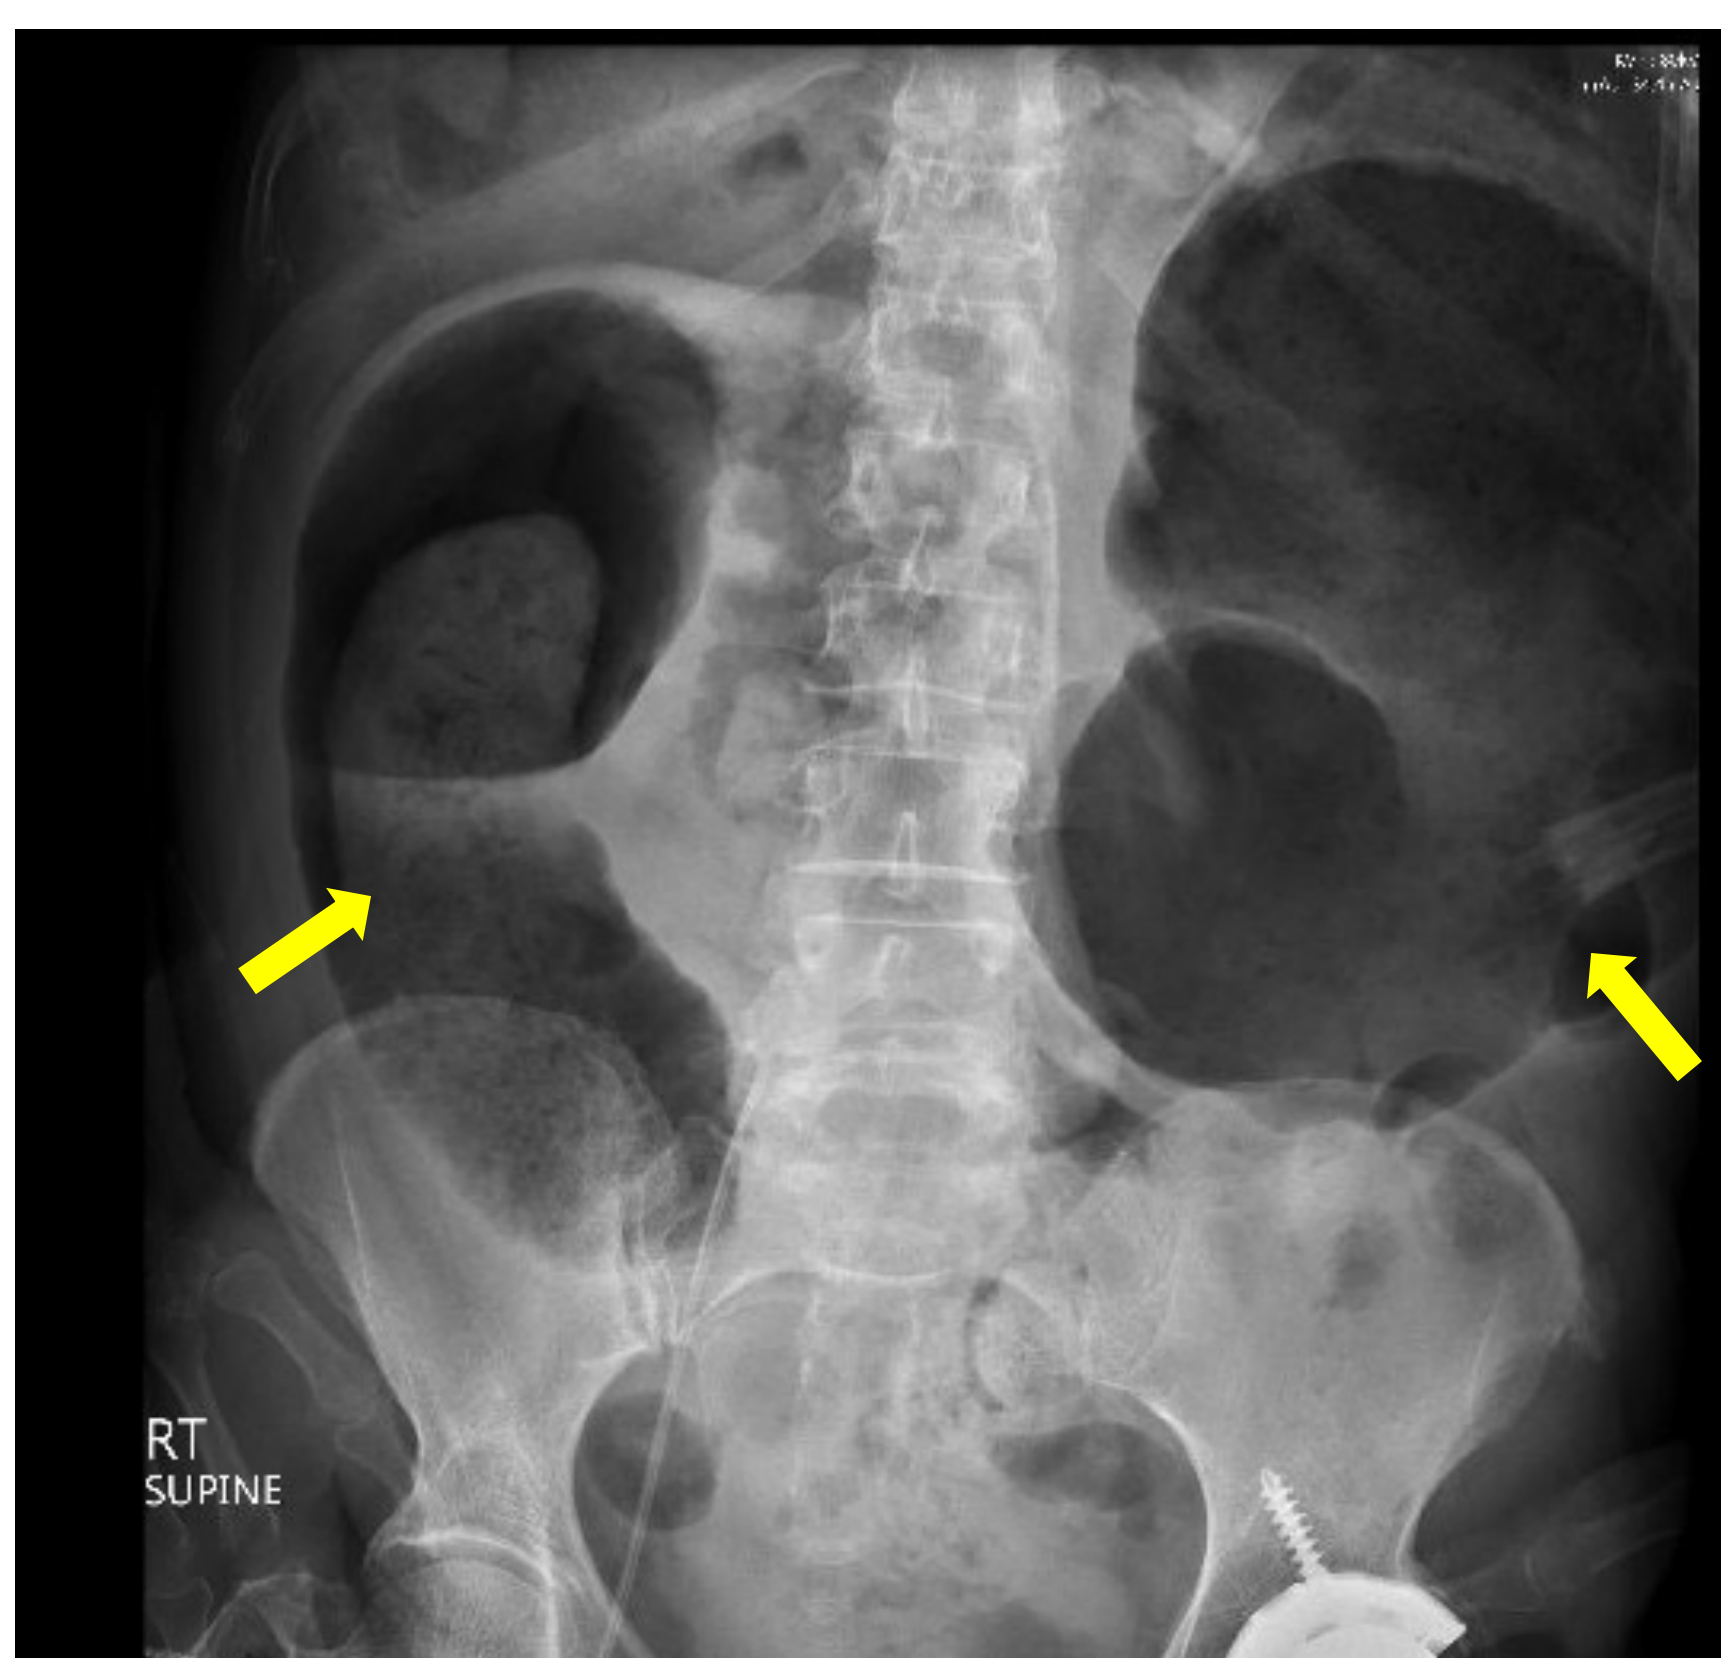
Xray Abdomen showing dilated bowel (yellow arrows) possibly related to stercoral colitis.
